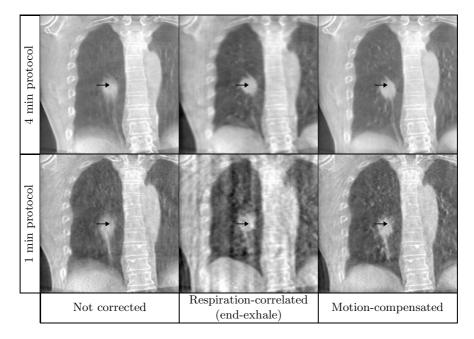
Coronal slices of reconstructed CBCT images from sets of CB projections acquired with the two different protocols. The motion-compensated CBCT images have been reconstructed without taking into account the setup error. Arrows indicate the isocenter, i.e. the tumor location.
